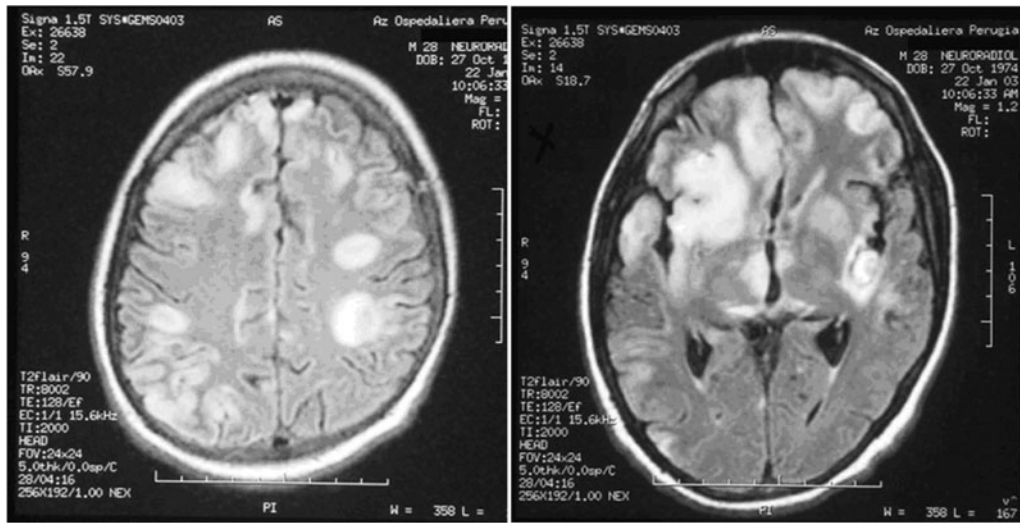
Brain imaging of patient (MRI, T2-weighted FLAIR), 75 days after admission, revealing relevant increase of supratentorial lesions, with clear hemorrhagic component.
